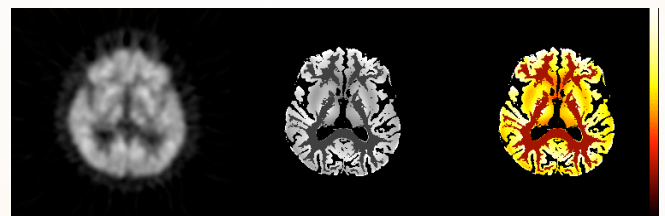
FDG-PET study from a normal subject (left) with corresponding PVE-corrected image (grayscale in the center and color-scale on the right).
